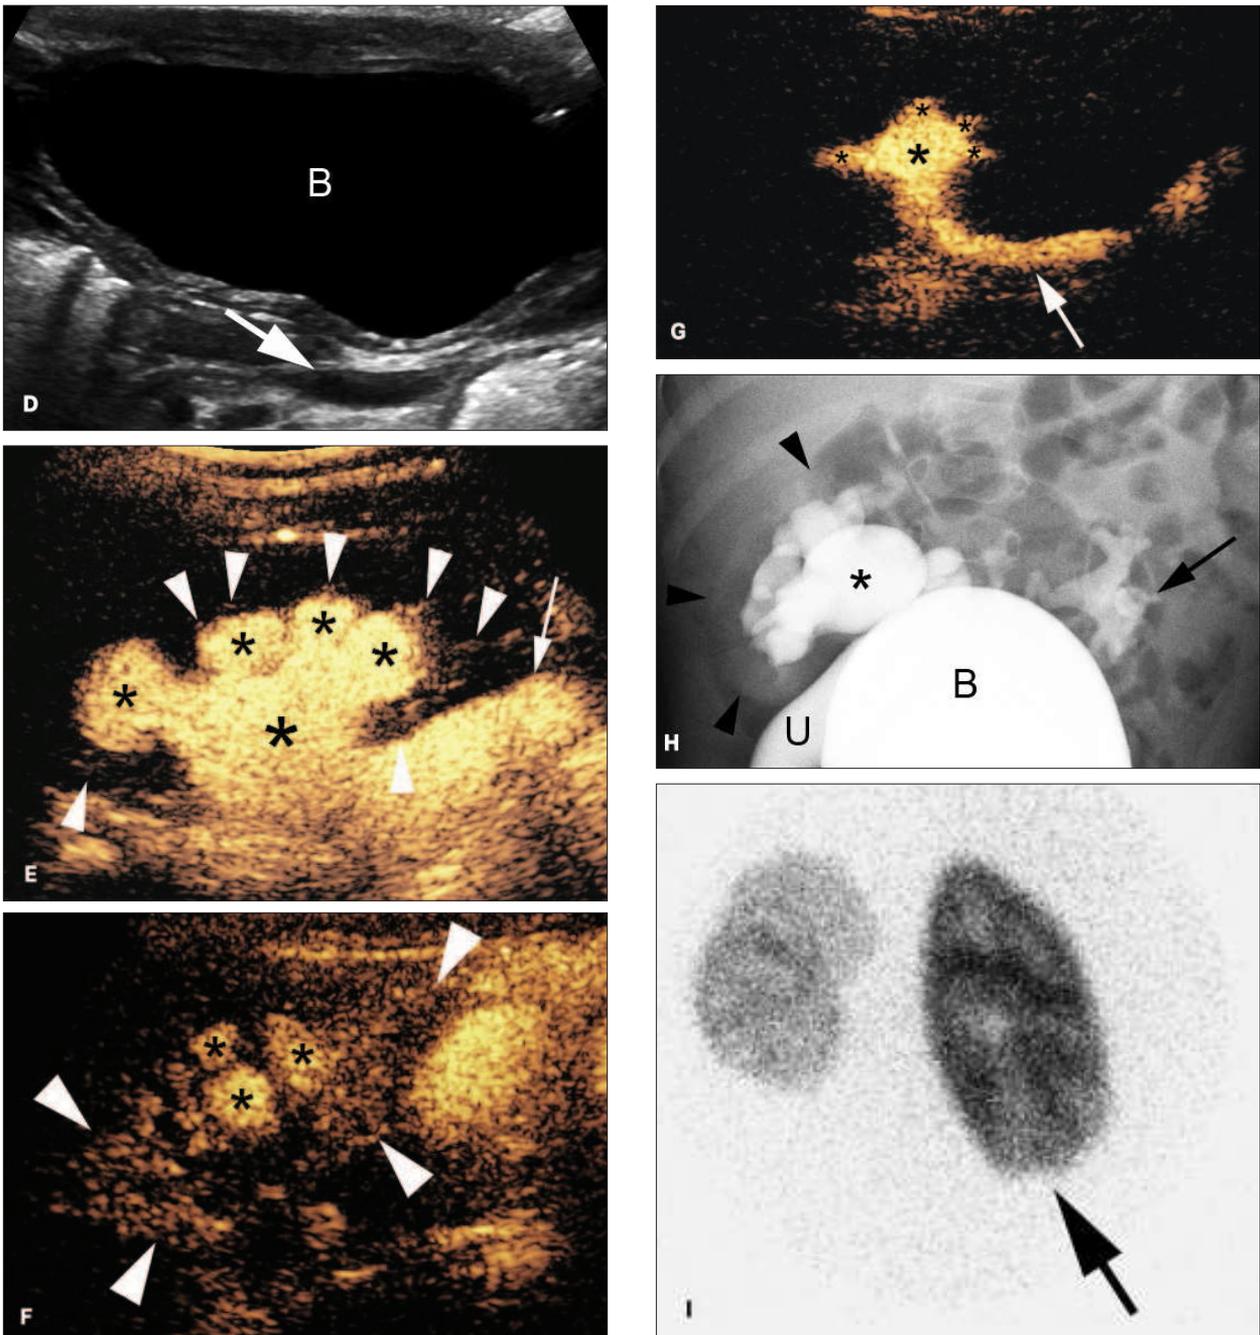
(continued) D, Sagittal sonogram shows mild dilation of the distal left ureter (arrow). E, Sagittal sonogram of the right flank during contrast-enhanced voiding urosonography shows contrast material filling a dilated, tortuous ureter (arrow) and a dilated renal collecting system with blunted calyces (asterisks). Multiple punctate and linear hyperechoic foci, in keeping with IRR, extend from the calyces into the adjacent renal parenchyma (arrowheads), most prominently from the lowermost calyx. F, Sagittal sonogram of the right kidney during contrast-enhanced voiding urosonography depicts widespread renal parenchymal enhancement at the peak of reflux due to IRR (arrowheads). Asterisks indicate dilated calyces. G, Sagittal sonogram of the left flank during contrast-enhanced voiding urosonography reveals contrast material within a mildly dilated ureter (arrow) and renal collecting system (asterisks). There is no IRR, and the surrounding renal parenchyma appears dark. H, Anteroposterior supine image of the abdomen and pelvis during VCUG shows grade V right-sided VUR with a dilated ureter (U), pelvis (asterisk), and calyces. There is extensive right IRR (arrowheads). Left-sided grade II to III VUR is also present (arrow). I, Posterior oblique pinhole image of the right kidney on Tc-99m-DMSA scintigraphy shows mild lower pole parenchymal thinning (arrow).
